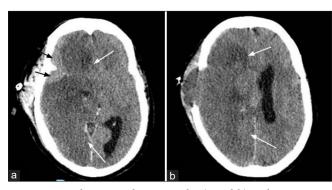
Head computed tomography (a and b) without contrast axial images 5 days postoperative showing a complete acute ischemic stroke in the distribution of the right middle cerebral artery (white arrows). Black arrows indicate the subdural tumor collection at the sphenoid wing/Sylvian fissure region.
